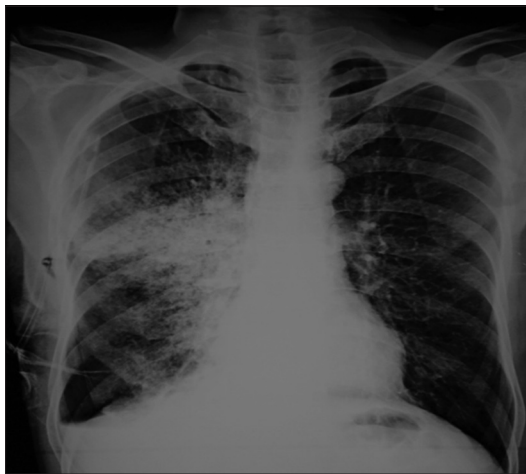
Chest X-ray showing homogenous opacity on the right side with intercostal tube in place and minimal pneumothorax
